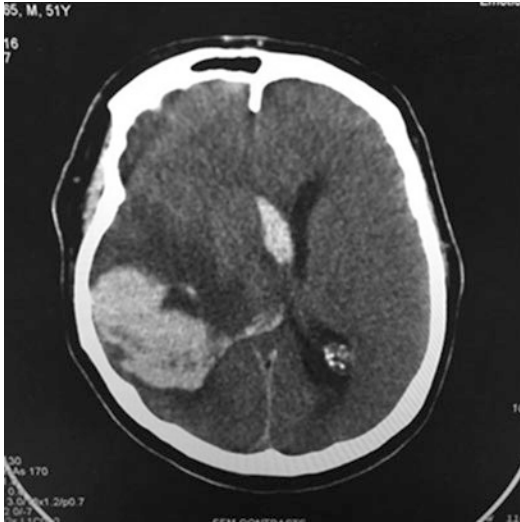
CT scan showing cerebral hemorrhage
